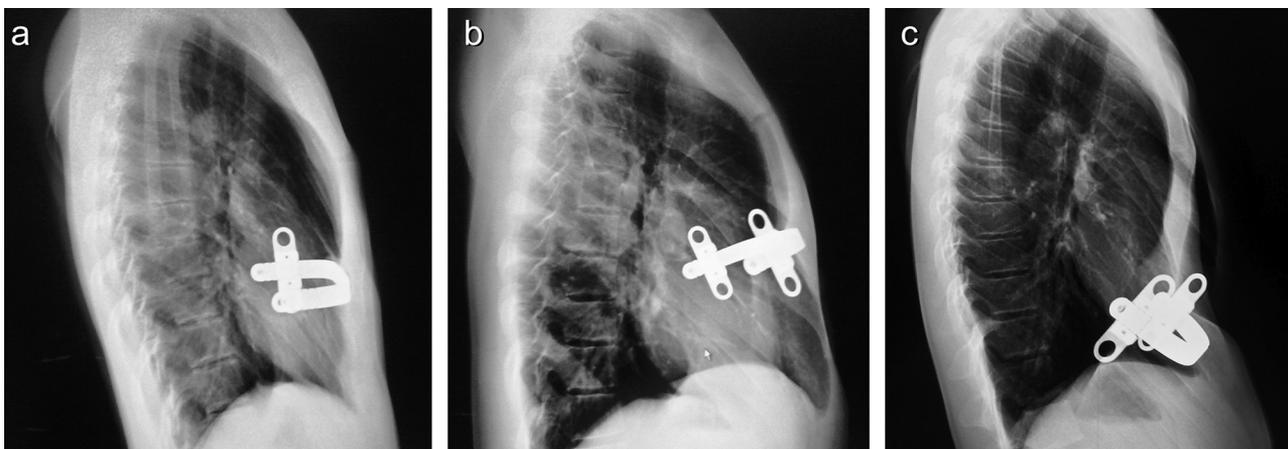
Postoperative lateral chest roentgenograms in 3 different patients: (a) patient with a Nuss bar in place: the angle formed by the bar with horizontal line is less than 15 degrees. (b) Patient with a Nuss bar mildly dislocated (angle between 15 and 30 degrees). (c) Patient with a Nuss bar moderately dislocated (angle between 30 and 60 degrees) which required an early bar removal.
